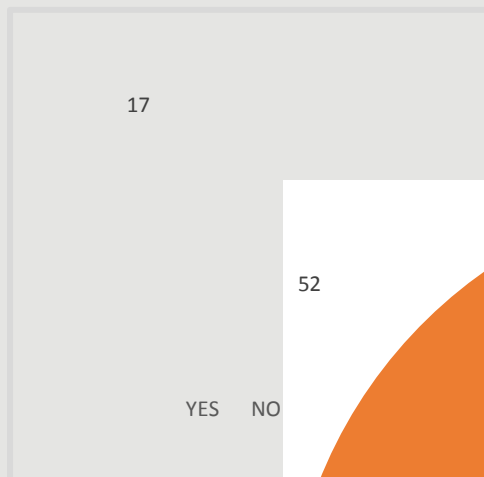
Showing the frequency of examinations in paediatric radiography
